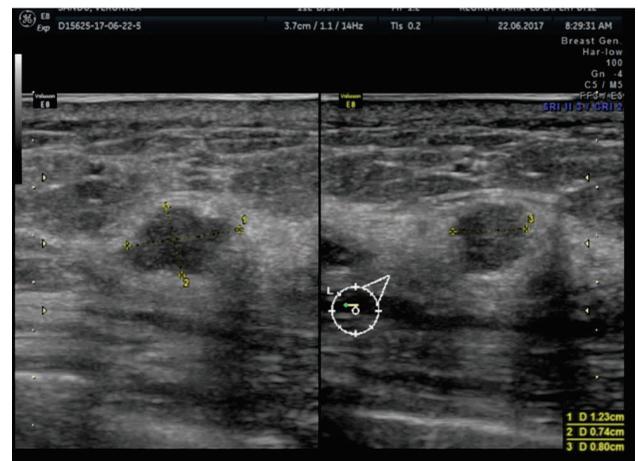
Ultrasonographic aspect of a 39 years-old patient with BI-RADS 3, ACR-C density and diagnosis of lobular breast carcinoma
